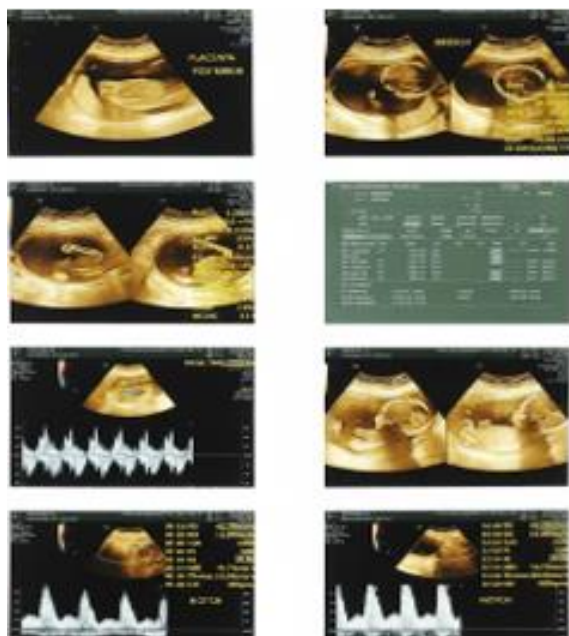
Colour and pulsed Doppler ultrasound at 26-week of gestation showing uterine artery notching and elevated resistance index – suggestive of uteroplacental insufficiency.
